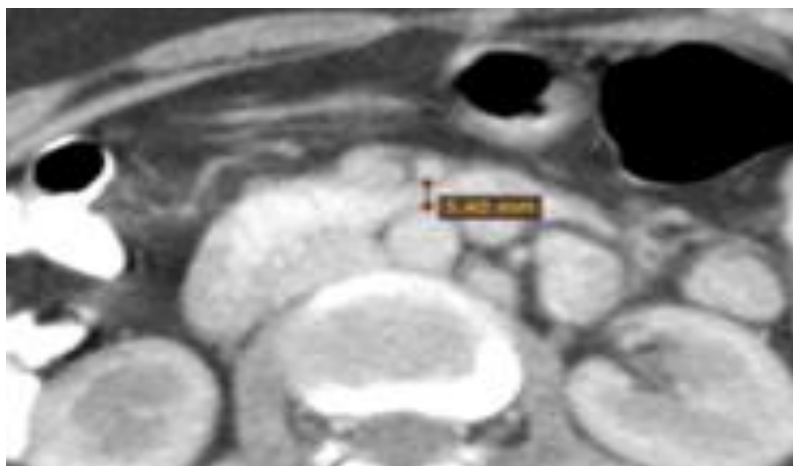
CT scan axial section of Superior Mesenteric Artery
